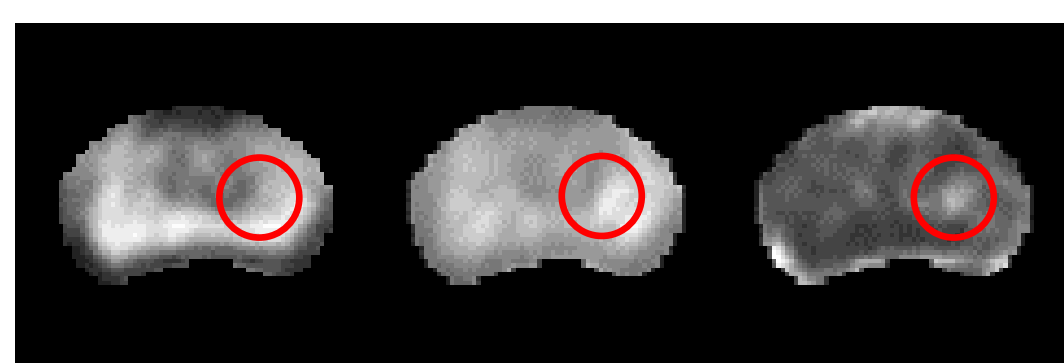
Calculated DWI scans with b-value of 0, 2000 and 4000 from left to right respectively. Red circle marks diagnosed cancer.
